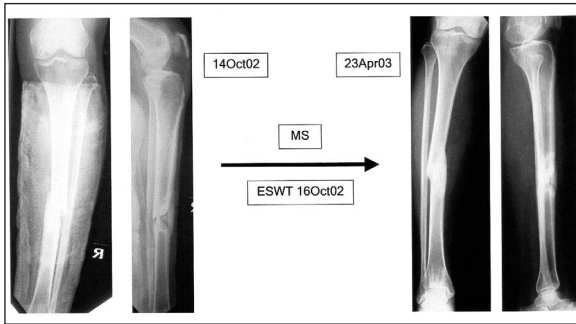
Radiographs before and after ESWT for patient MS
